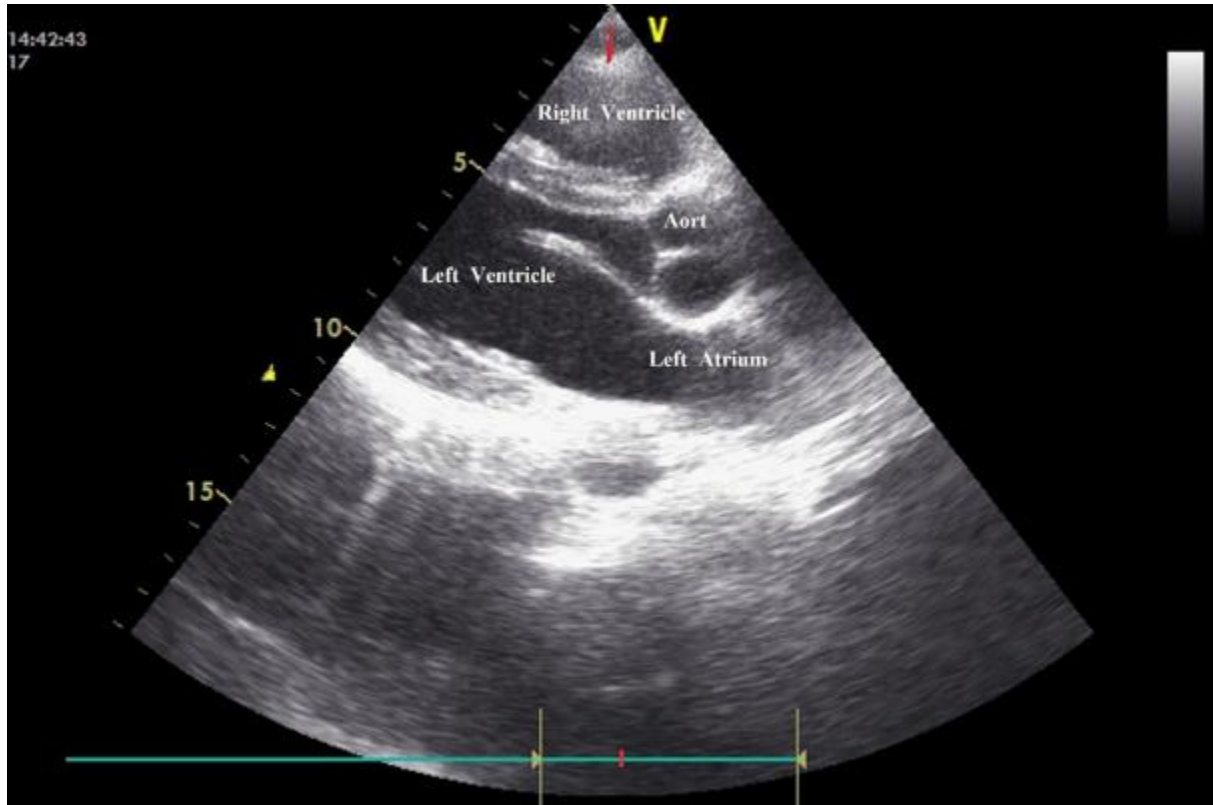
Measurement of epicardial fat tissue thickness (EFTt) by two-dimensional transthoracic echocardiography
